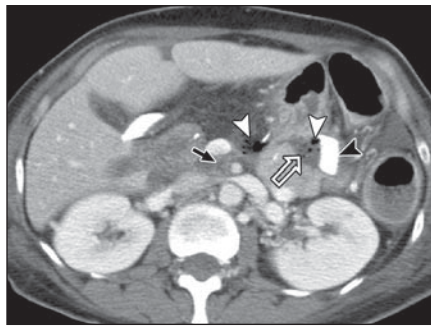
54-year-old woman 7 days after pancreaticoduodenectomy for pancreatic adenocarcinoma. Transverse contrast-enhanced helical CT scan of abdomen shows perianastomotic fluid collection close to anastomosis (open arrow) and containing air bubbles (white arrowheads). Drain (black arrowhead) is next to anastomosis. Black arrow indicates perivascular cuffing surrounding superior mesenteric vessels. Patient had clinicobiologic diagnosis of pancreatic fistula on postoperative day 7. Both radiologists made correct diagnosis.
